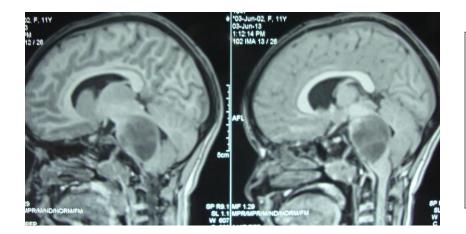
MRI BRAIN SHOWING DIFFUSE INTRINSIC BRAIN STEM LESION WITH ENLARGEMENT OF THE BRAIN STEM.
